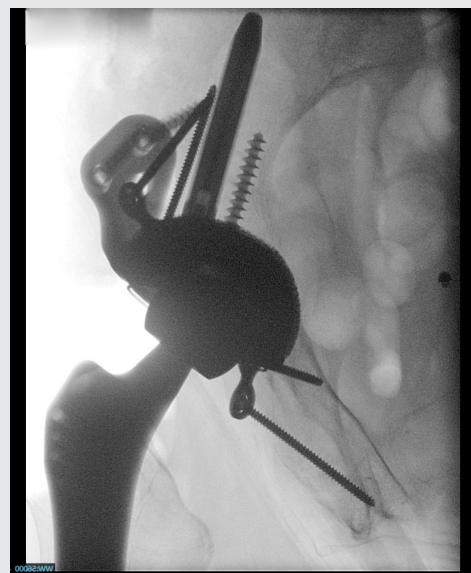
Intraoperative X-ray control of the implant position
